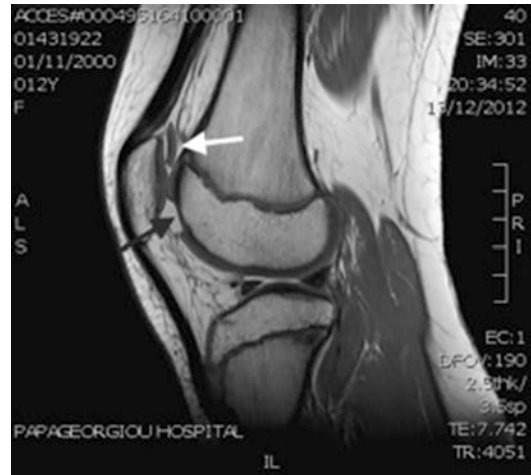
MRI scan (sagittal view) 3 months after patellar dislocation. A large chondral fragment is in the supra-patellar space (white arrow). The fragment comes from the lateral femoral condyle (black arrow)
